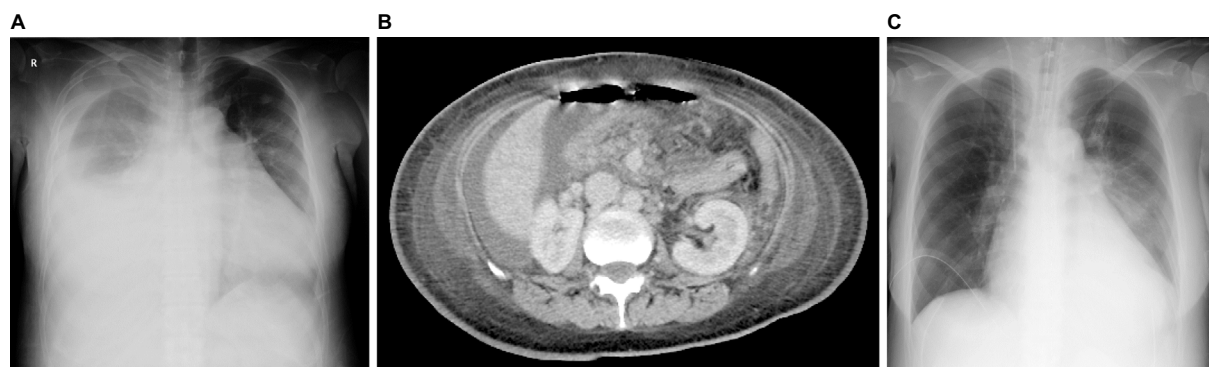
Chest X-rays films and contrast-enhanced computed tomography. (A) The chest X-ray on presentation to previous hospital showed marked cardiomegaly with bilateral pleural effusions that were larger on the right side. (B) Contrast-enhanced computed tomography on presentation to the previous hospital (before surgery) revealed free air in the peritoneal cavity with edematous duodenum and ascites. (C) The chest X-ray on discharge from the intensive care unit showed a marked improvement of heart failure.
